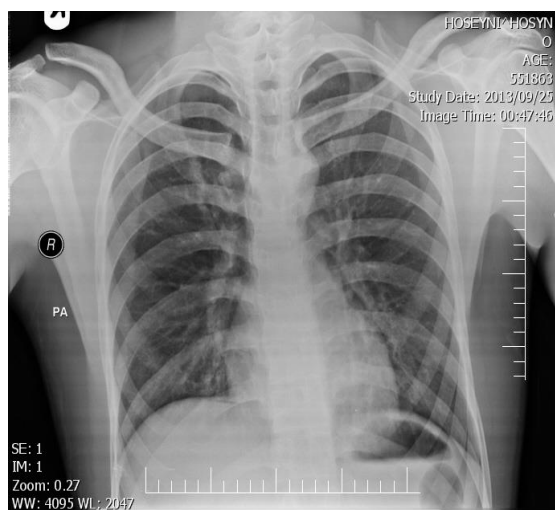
Upright chest radiography. There is free subdiaphragmatic air.
